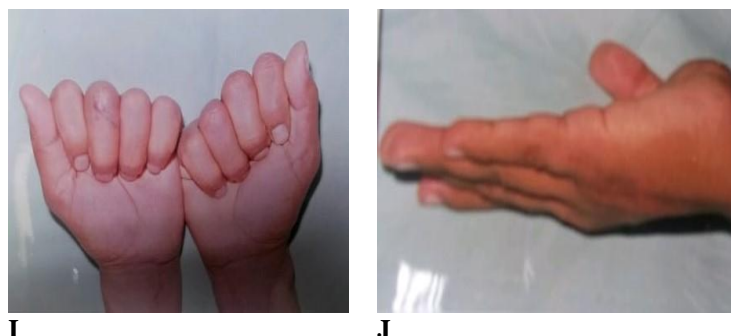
shows a 22-year-old male student who fell and fractured the fifth metacarpal of his nondominant left hand in a short oblique fashion. Cases where the outcome was positive include: X-rays taken before surgery (A, B), right after surgery (C, D), at the end of follow-up (E, F), with full range of motion and no discomfort or deformity in the left little figure (G, H, I, J) P.I.P. flexion (in degrees): 100 T.A.M.
